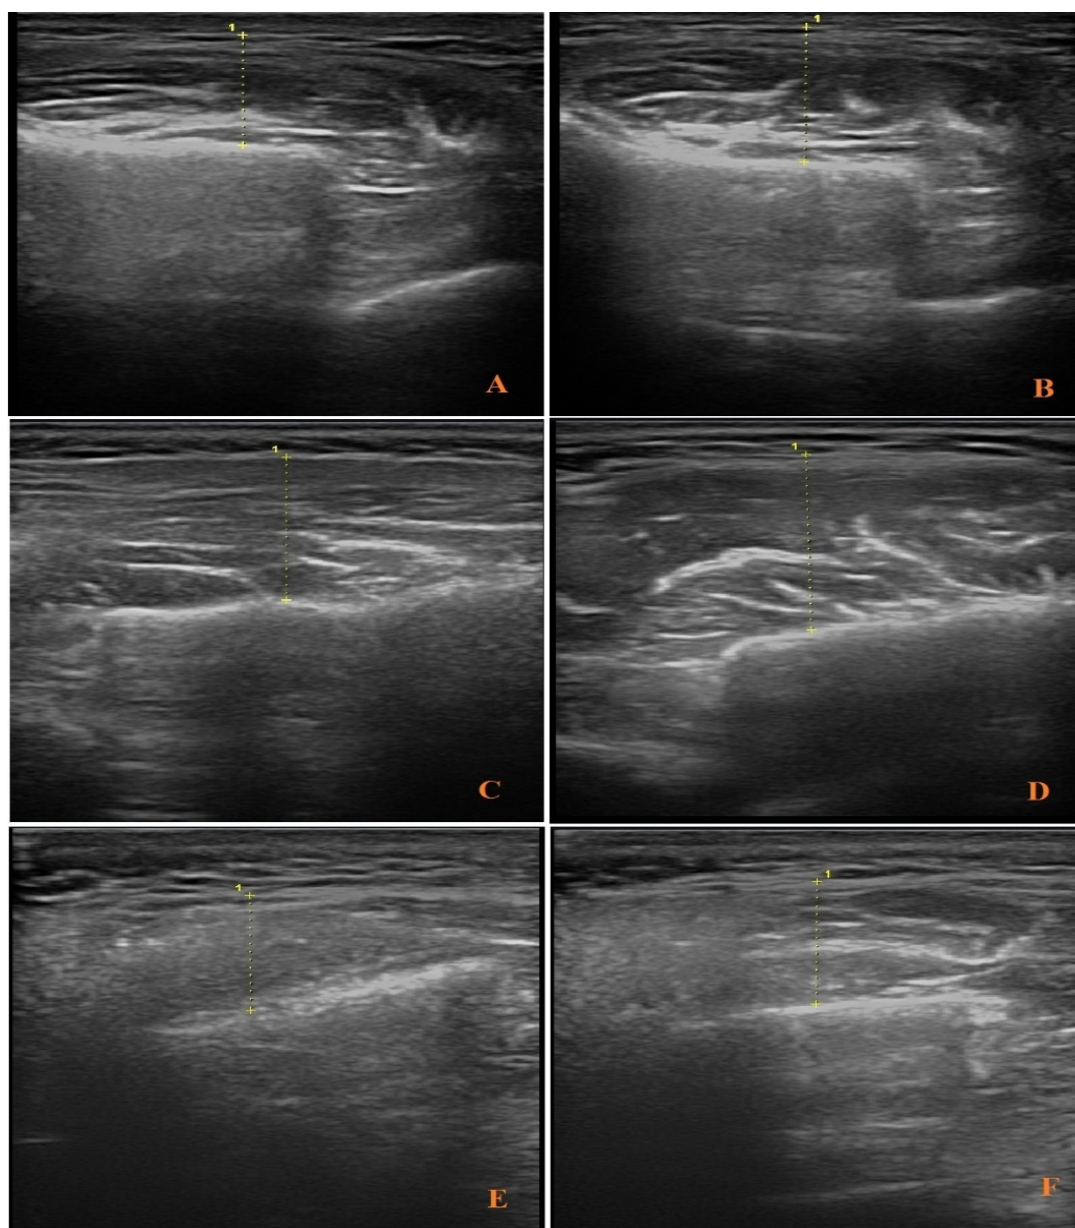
Ultrasound view of the masseter muscle. A-B: Normal view (group I internal pattern) in a 16-year-old boy with CL II malocclusion: thin and thick hyperechoic bands are well visible. A: Muscle sonogram at rest: muscle thickness: 1.06 cm. B: Muscle sonogram in contraction state: muscle thickness: 1.33 cm. C-D: Sonographic view (group II internal pattern) in a 17-year-old female with CL III malocclusion: reduction of fine bands and reduction of residual echo bands. C: Muscle sonogram at rest: muscle thickness: 1.42 cm. D: Muscle sonogram in contraction state: muscle thickness: 1.78 cm. E-F: Sonographic view of group III (abnormal state) in an 18-year-old female with CL I malocclusion: severe reduction of muscle bands. E: Muscle sonogram at rest: muscle thickness: 1.15 cm. F: Muscle sonogram in contraction state: muscle thickness: 1.22 cm.
